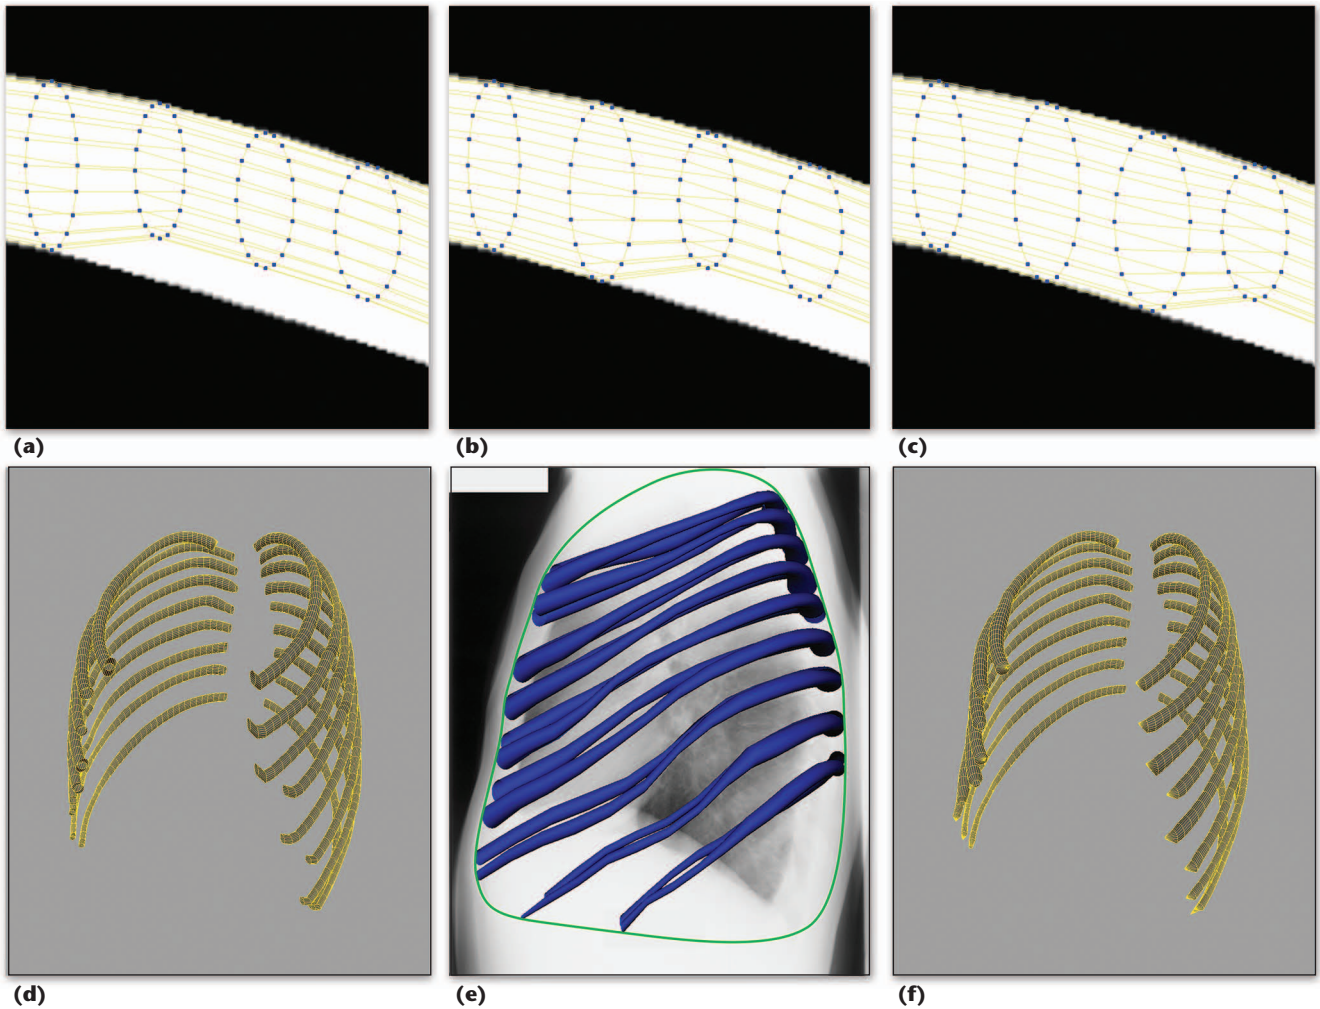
Refinement of a rib reconstruction: (a–c) radial vertex clusters scaled so that their projections align with a segmented rib’s two opposing edges at different stages as the algorithm processes every radial cluster sequentially, (d) the reconstructed rib cage after the first pass of vertex cluster transformation, (e) rib templates translated and scaled to align with the segmentation of the lateral rib cage projection, and (f) the final reconstructed rib cage. These are the required steps for aligning the ribs to the lateral x-ray image.v
